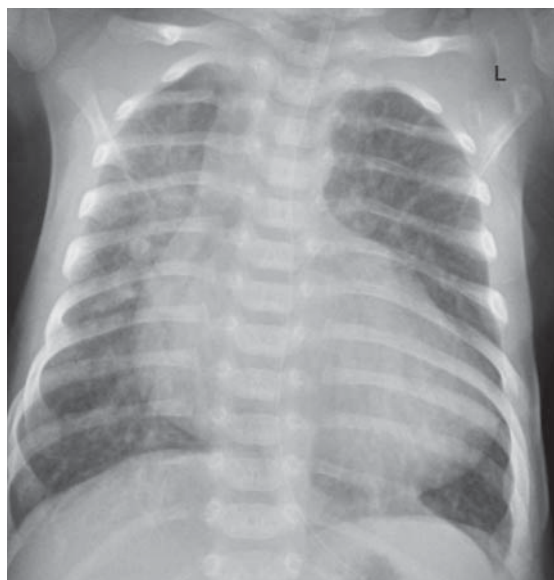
Chest X-ray of transposition of the great arteries. Note the characteristic egg-on-side appearance with oligemic lung fields.
